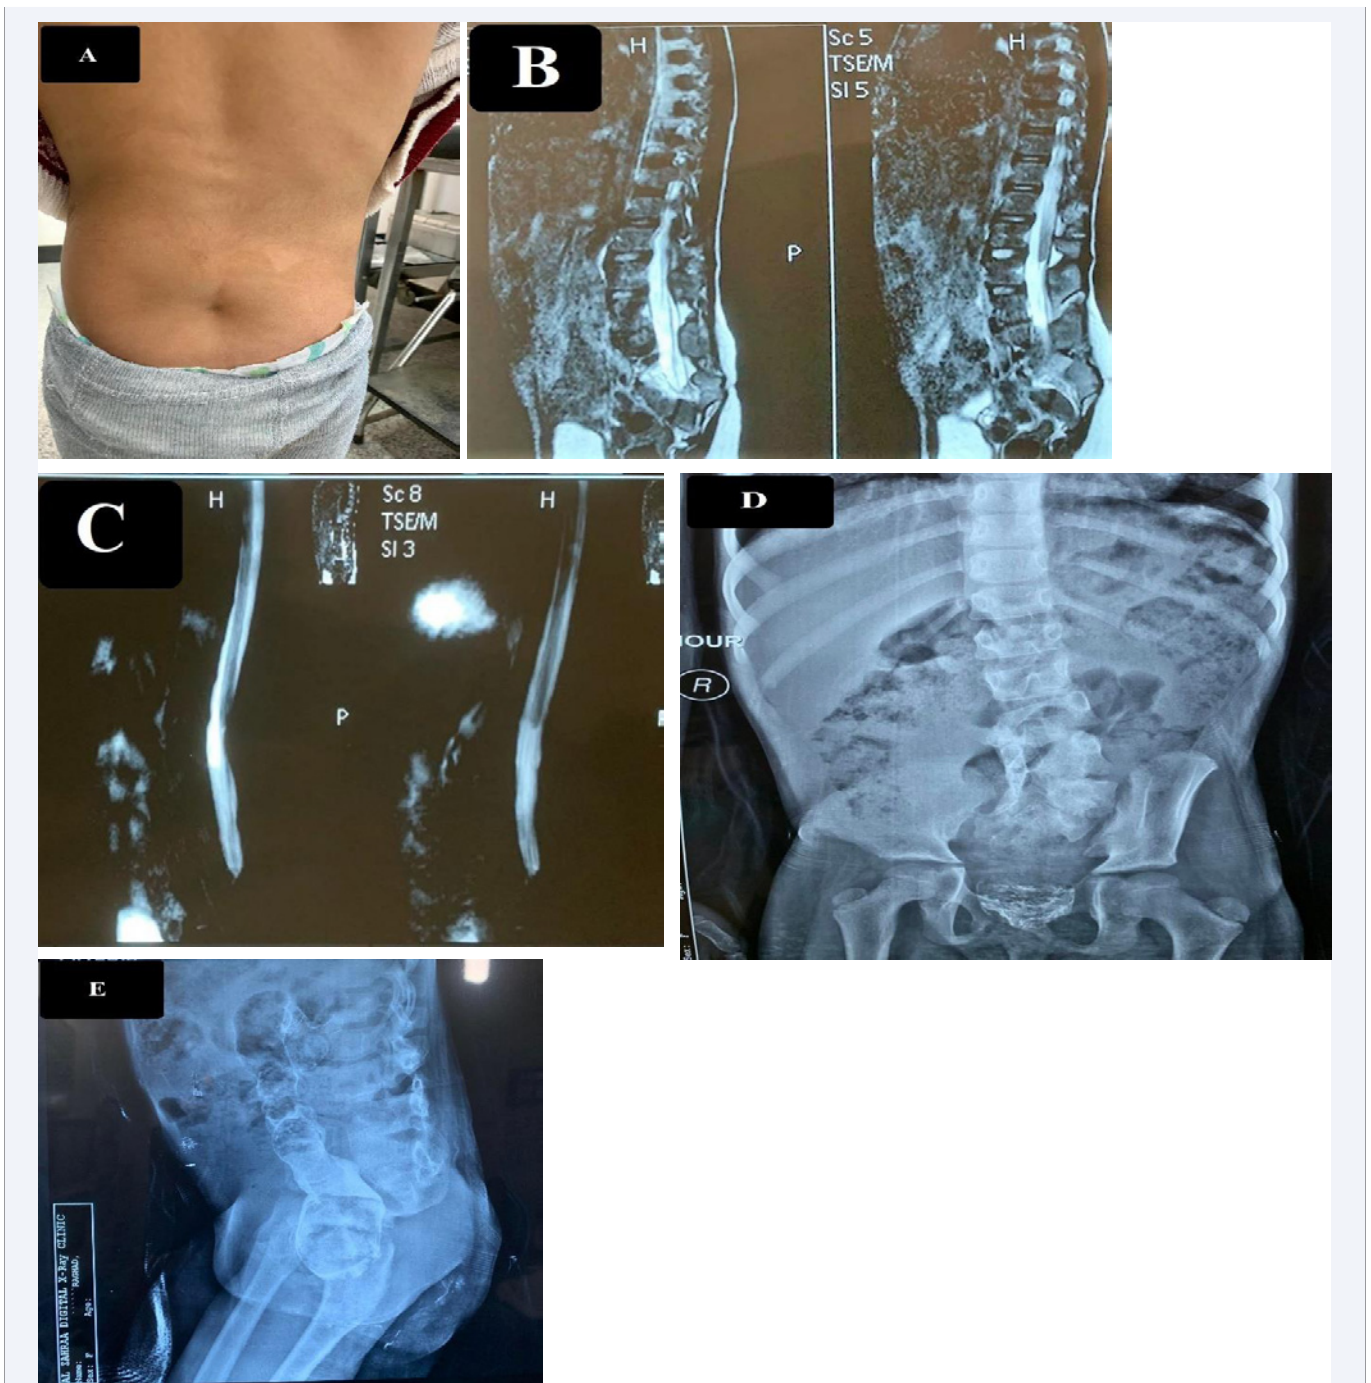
A, B, C, D and E; A: flat buttocks, and a dimple over the sacral area. B&C: MRI of the vertebral column revealed sacrococcygeal hypoplasia with a blunt-ending, club-shaped conus medullaris terminating at the T11-12 vertebral level. The caudal nerve roots were arranged in anterior and posterior bundles (Renshaw type 2). D&E: Barium enema revealed impacted stool filling the sigmoid colon and rectum, markedly distended recto sigmoid colon is obvious on these sequences, and signs of sacral agenesis.
